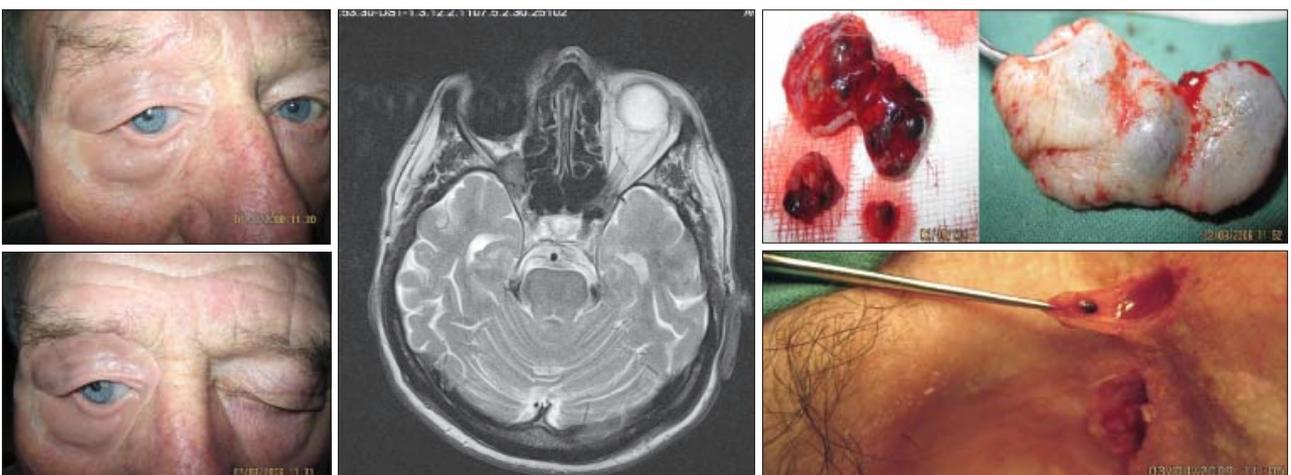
a) The patient has an individual epithesis (prosthesis) of the right orbital side, b) Magnetic resonance imaging half year after exenteration, without progression to ethmoids, c) One year after radical operation; an extension of relapsed melanoma nodule was present on the temporal margin of orbit and in the nasal part. Excision of multiple melanoma nodules twelve months after exenteration, d) Excision of relapsing subcutaneous orbital melanoma – melanoma nodules – eighteen months after the exenteration of orbit.
